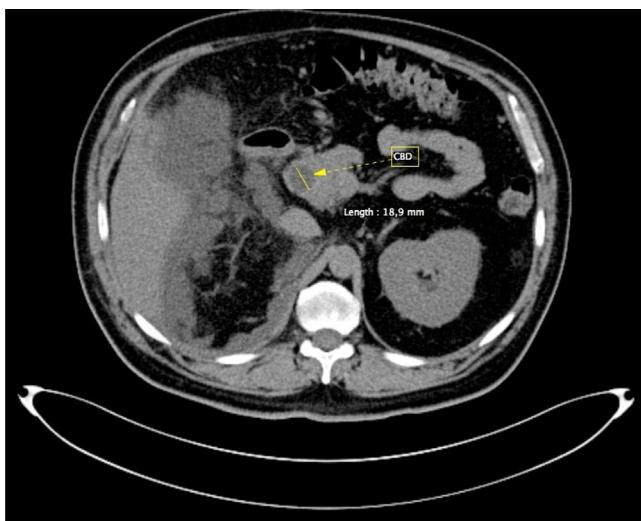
CT scan shows free peri-renal fluid, in the Morrison space and, as well as dilation of the common bile duct (CBD).
